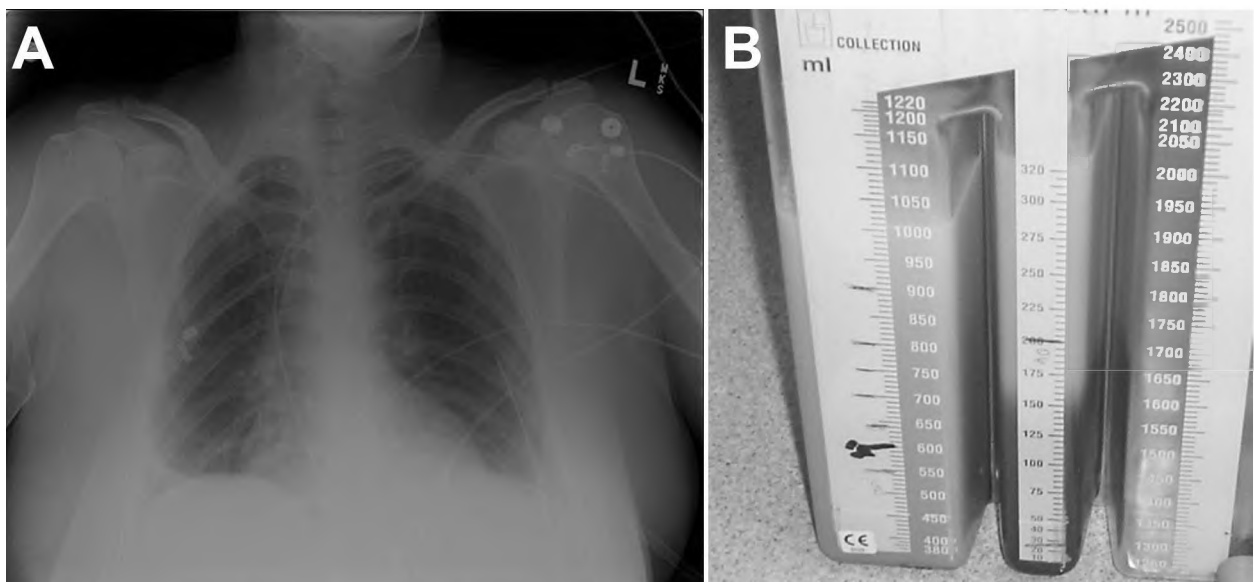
A: Chest x-ray study demonstrating a small fluid collection obliterating the costodiaphragmatic angle. B: Photograph of a Pleurovac container showing the white, milky, creamy fluid collection from the pleural space.
